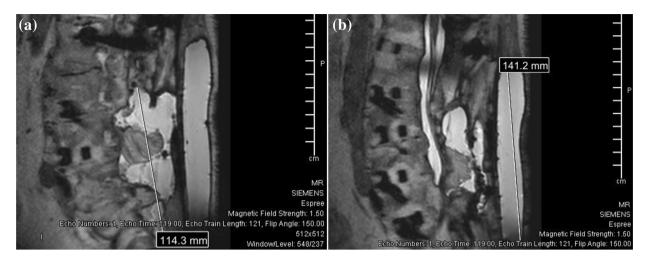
a A T2-weighted sagittal magnetic resonance image demonstrating the extent of the pseudomeningocele. A cranio-caudal measurement of the subfascial component of the pseudomeningocele is included. b A T2-weighted
